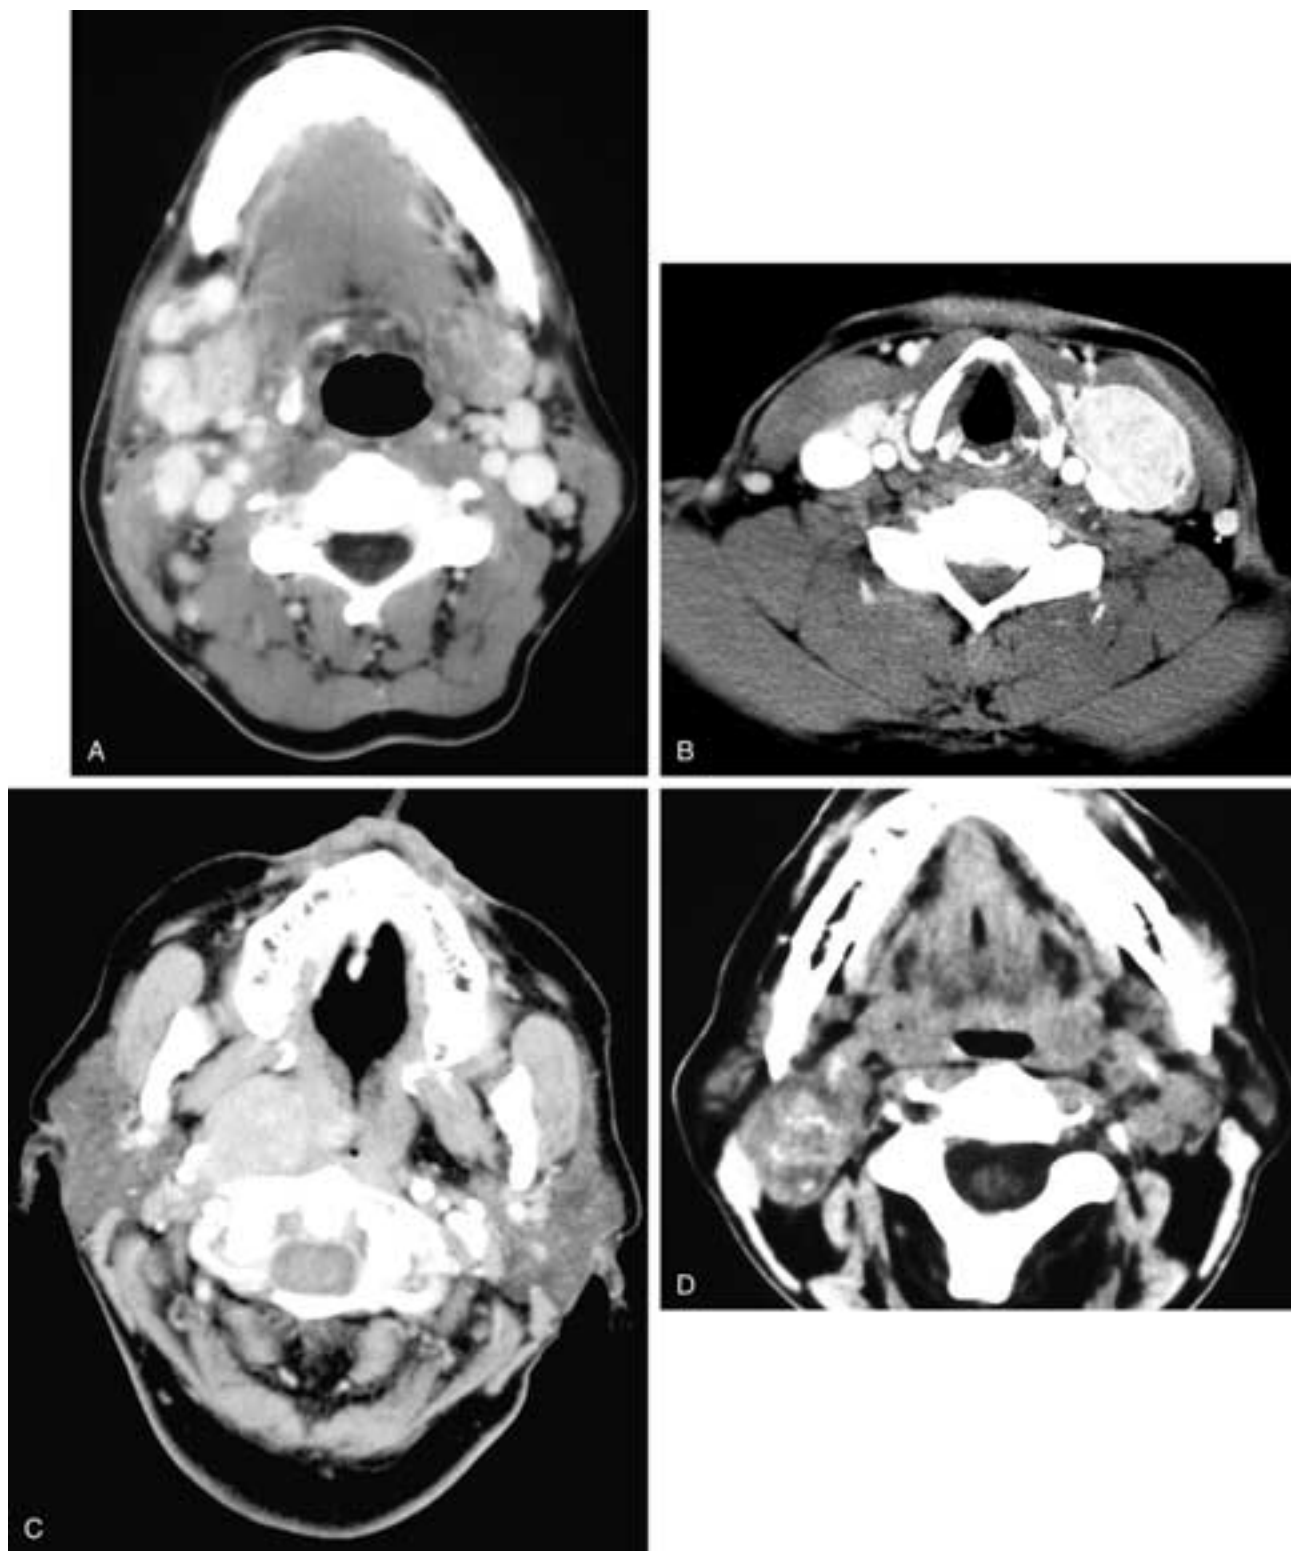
Contrast-enhanced CT scans on four different patients. In A, there are multiple right, densely enhancing level I and II nodes. There are also bilateral smaller, posterior level II nodes that enhance to a lesser degree. The larger right-sided nodes were metastatic papillary thyroid carcinoma. The smaller posterior nodes were reactive. In B, there is an enlarged, densely enhancing left level III node that was a metastatic papillary thyroid carcinoma node. In C, there is an enlarged, enhancing right retropharyngeal node that was a metastatic papillary thyroid carcinoma node. In D, there is a right, enlarged, and enhancing level II node with calcifications in this patient with metastatic papillary thyroid carcinoma.
